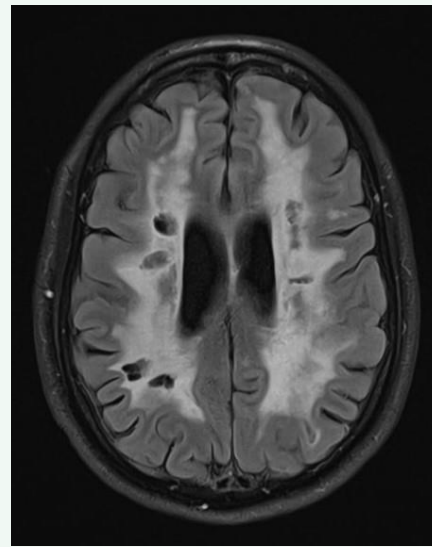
Axial T2/FLAIR MRI demonstrating confluent periventricular white matter disease.
